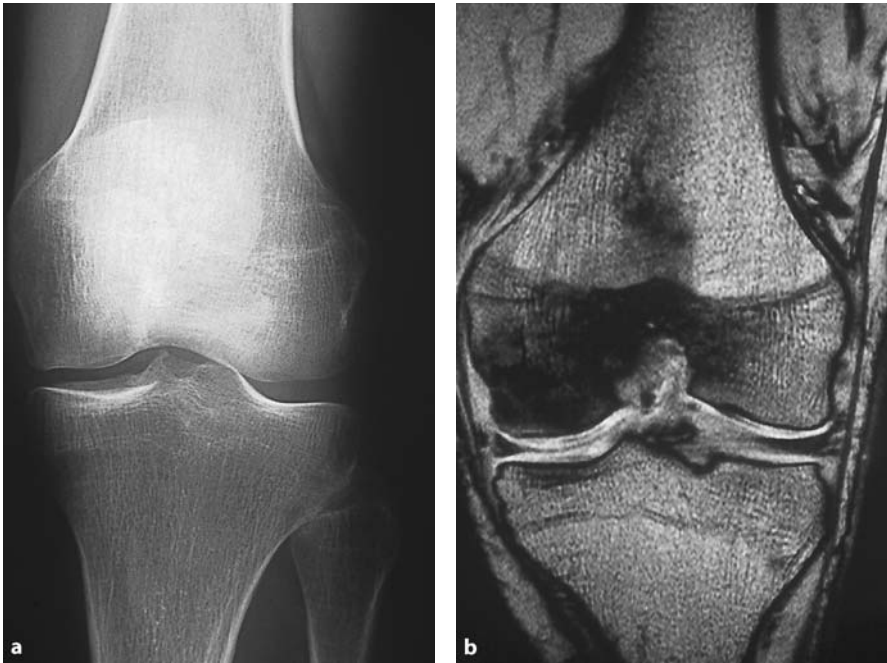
Transient osteoporosis in the region of the distal femur. a No abnormalities visible on X-ray. b Widespread edema of bone marrow on MRI, T1-weighted
